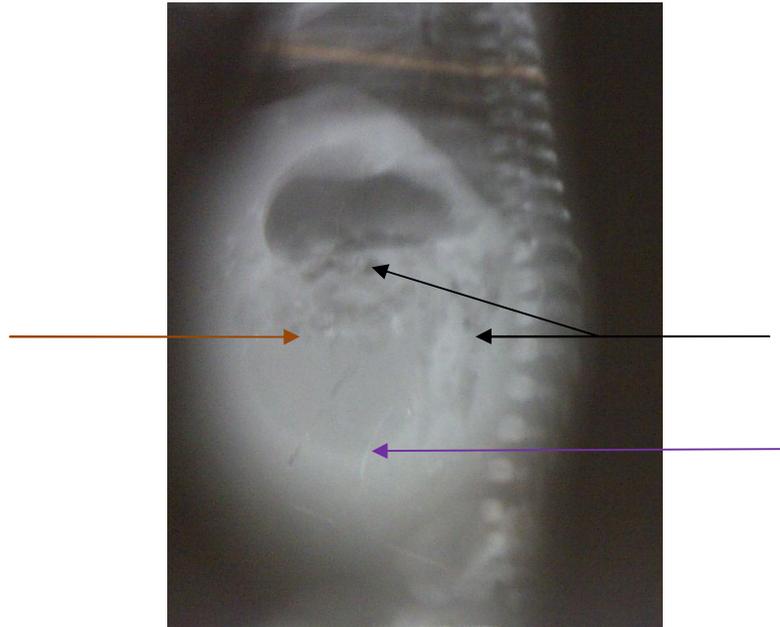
Abdominal Radiograph (Black Arrow Points to Pseudocysts, Brown Arrow Indicates Calcification and Purple Arrow Shows Ground Glass Appearance of the Abdomen)
